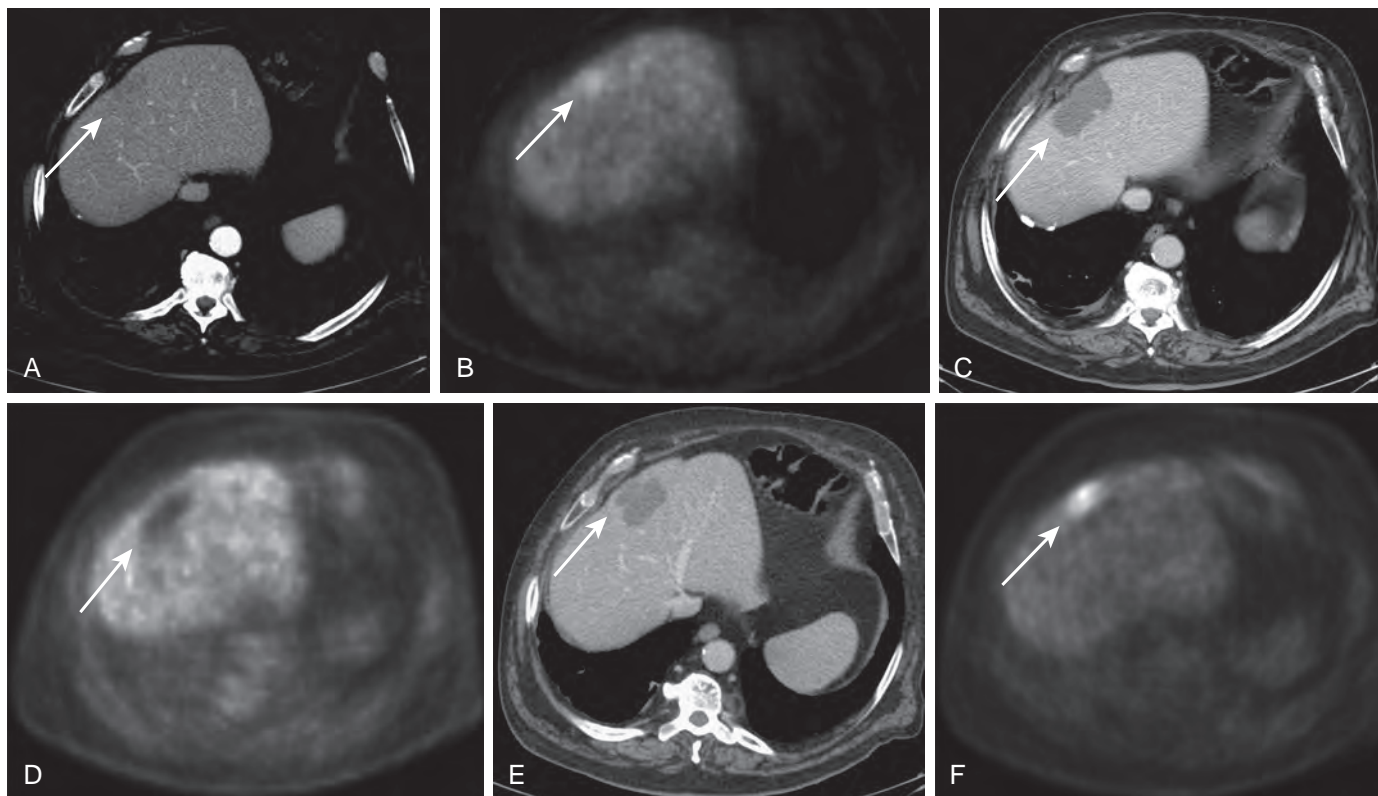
Recurrent hepatic tumor. Contrast-enhanced CT demonstrates an ill-defined low-attenuation lesion in the periphery of the liver (A, arrow), which demonstrated increased FDG avidity on PET (B, arrow). Biopsy confirmed a metastasis from colon cancer, which was treated with radiofrequency ablation. Contrast-enhanced CT 1 month after ablation demonstrated a nonenhancing low-attenuation ablation zone (C, arrow), which is photopenic on PET (D, arrow), consistent with treatment response. Contrast-enhanced CT 9 months after ablation demonstrates a low-attenuation area adjacent to the ablation zone (E, arrow), which demonstrated increased FDG avidity (F, arrow). Findings are consistent with local recurrence.
